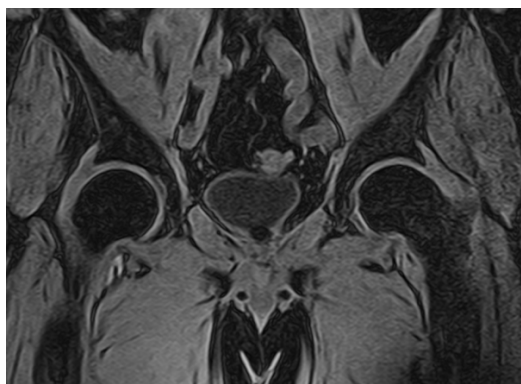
MR image of a non-displaced concrection, which was 3 cm in diameter, fixed to the posterior wall of the urinary bladder cervix
